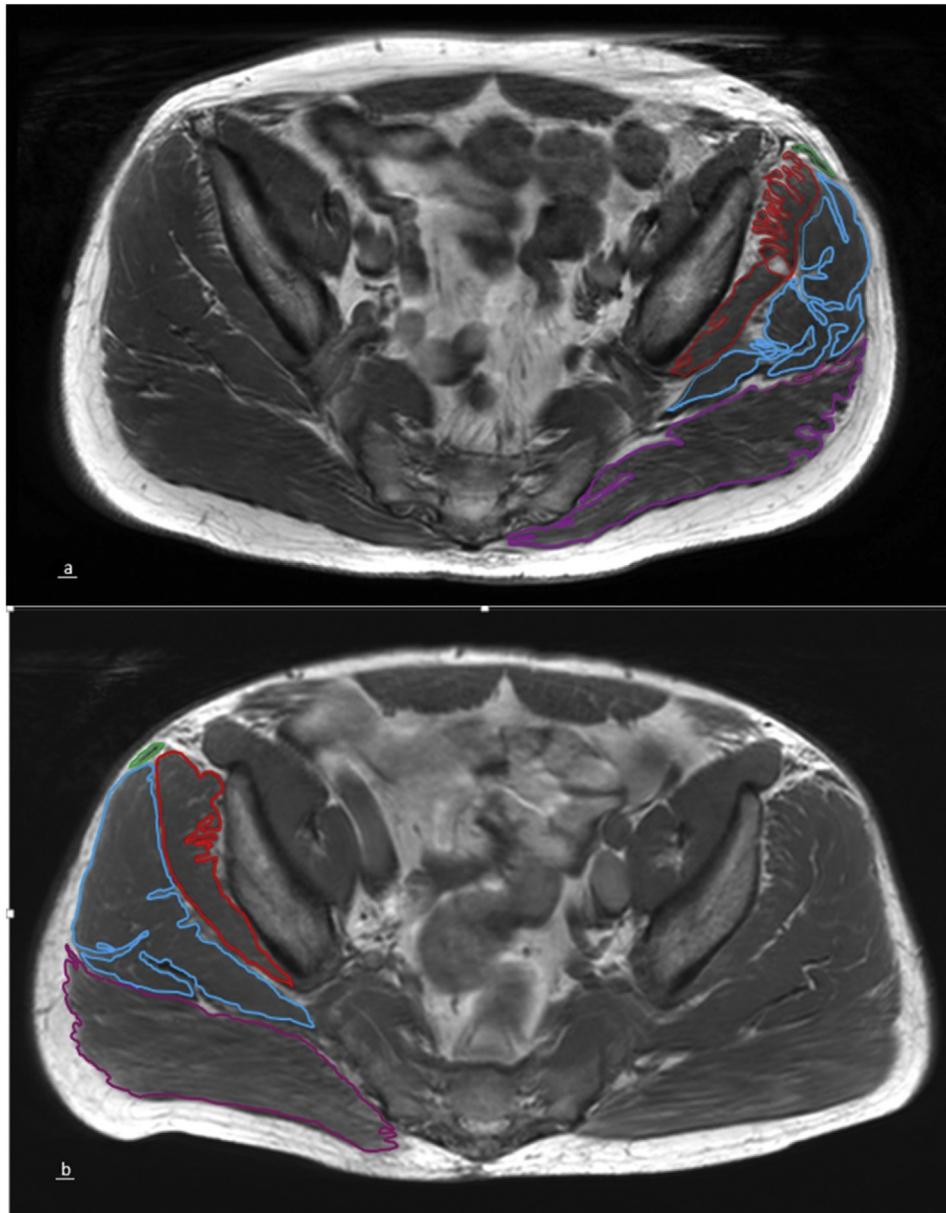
MRI tracings for muscle volume calculation in GMax (red), GMed (blue), GMin (green) and TFL (purple); (a) Left hip OA (b) Right hip matched control.
